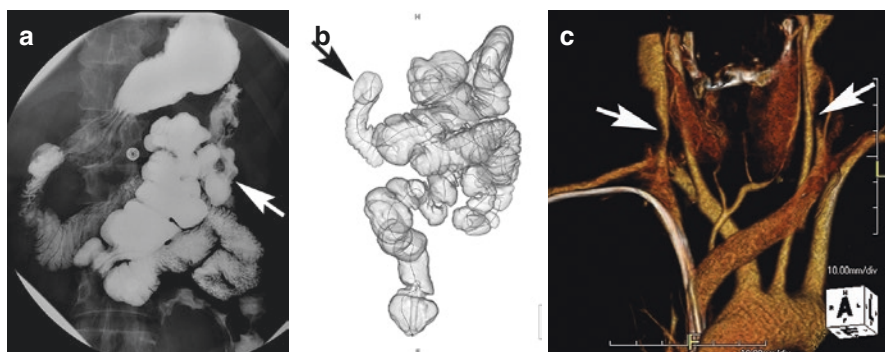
Pre-intestinal transplant evaluation in a 54-year-old man with short bowel syndrome. (a) Spot radiograph from a single-contrast upper gastrointestinal series shows a very short segment of the proximal jejunum is anastomosed to the colon (arrow). (b) Three-dimensional reconstruction of the colon from a CT scan performed with rectal CO₂ insufflation shows a jejunal to transverse colon anastomosis (arrow). Because of the short jejunum, CO₂ insufflation during the CT exam progressed retrograde to expand the first portion of the duodenum (arrow). (c) Three-dimensional vascular reconstruction of the aortic arch and neck blood vessels shows bilateral internal jugular vein stenosis (arrows)
